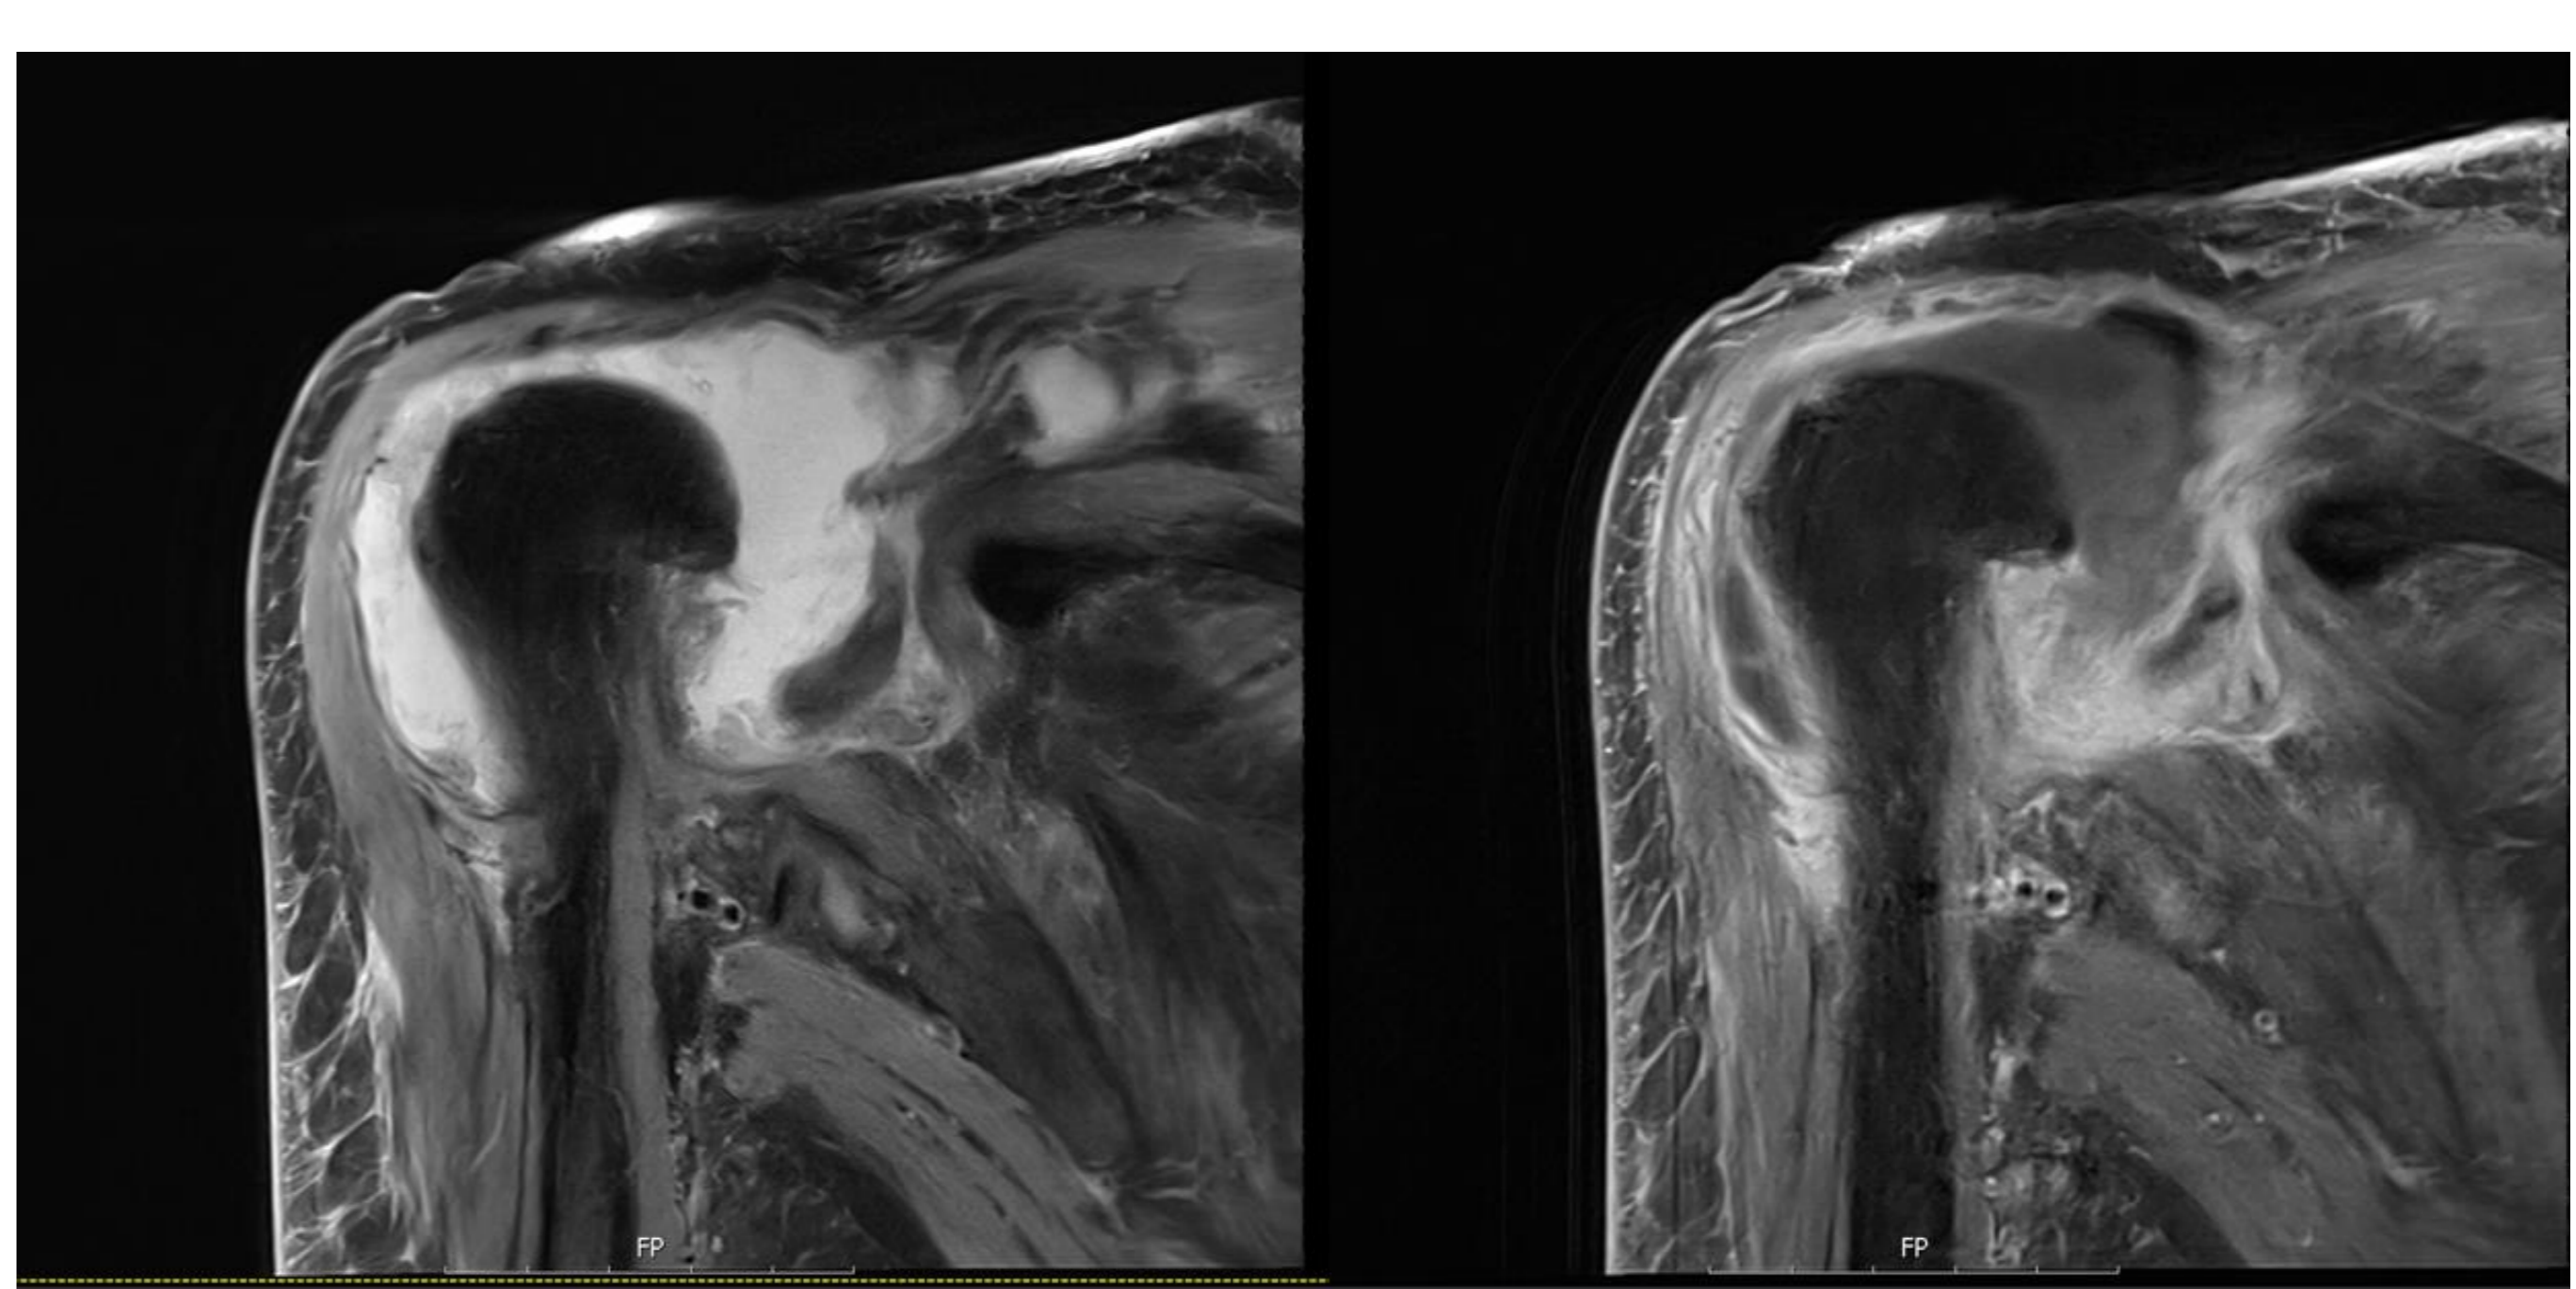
Coronal shoulder MRI. Left: T2-weighted image showing marked joint effusion. Right: T1-weighted fat-suppressed contrast-enhanced image demonstrating synovial enhancement.
